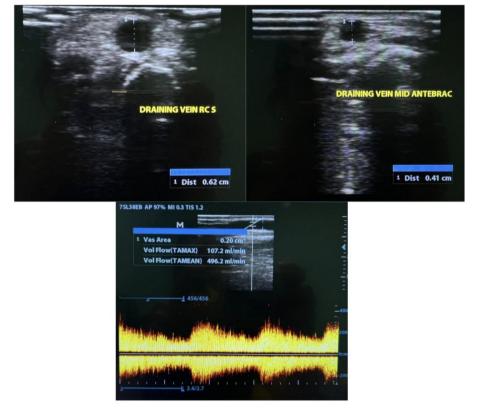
Postoperative duplex ultrasonography of the left radiocephalic AVF
